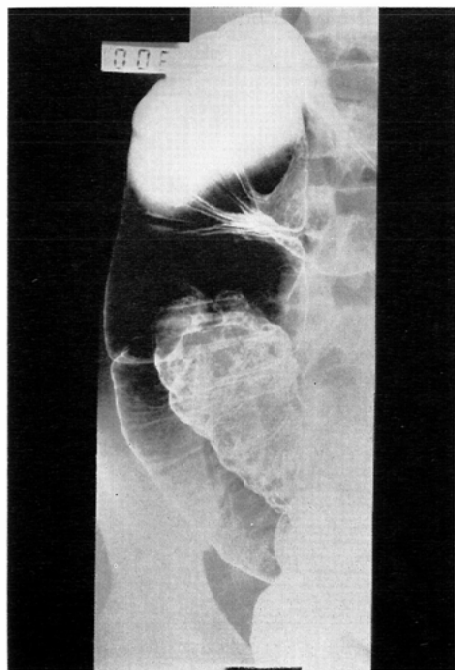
Case 1. Roentgenogram after a barium enema. A large tumor-like shadow (5×11 cm) protruding into the lumen of the ascending colon is seen. Its leading edge is depressed in the center.
